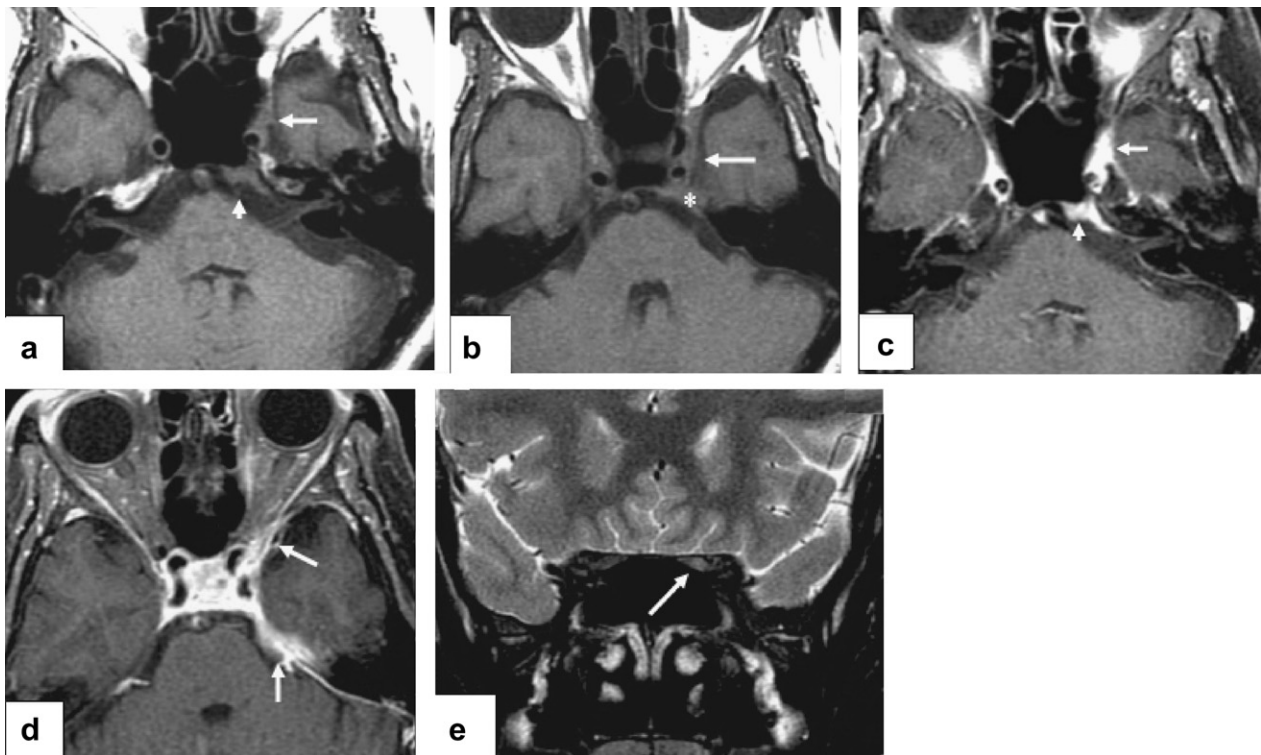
Case 1. Axial T₁-weighted MR images with fat suppression before (a,b) and after (c,d) gadolinium administration reveal an enhancing isosignal T₁ lesion along the left dorsal aspect of the clivus at the Dorello foramen (arrows in a and c) and along the left cerebellopontine angle cistern as well as the left tentorial sleeve and lateral cavernous sinus wall to the superior orbital fissure (arrows in b and d). The lesion also occupies the left Meckel's cave (white asterisk in b). A coronal fast spin-echo T₂-weighted fat suppression MR image (e) shows an abnormal hypersignal T₂ change of the left optic nerve (arrow in e), probably secondary to compressive ischaemic insult.
